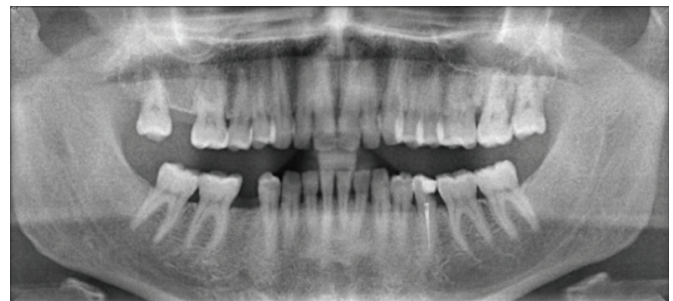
Panoramic radiography image of the patient.
